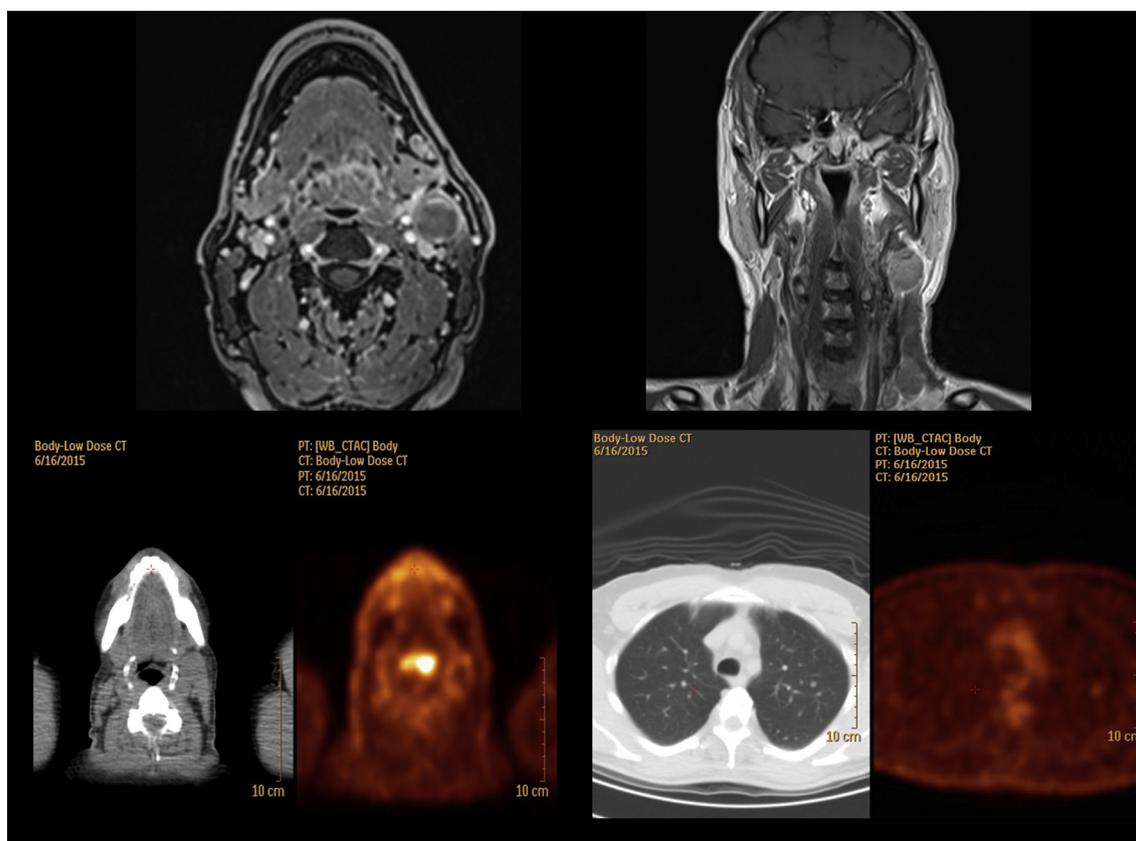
Axial and coronal images of contrast-enhanced, T1-weighted MR showing a hypointense lesion of the base of tongue crossing the midline with left cystic lymph nodes at levels II and IV (upper row). FDG PET-CT images showing intense hypermetabolism of the primary tumor, rim accumulation of tracer at level II lymph node and a solitary lung lesion in the apicoposterior upper left lobe with moderate hypermetabolism (lower row). Morphology and FDG uptake in a 7 mm lung nodule were suggestive of neoplastic origin.
